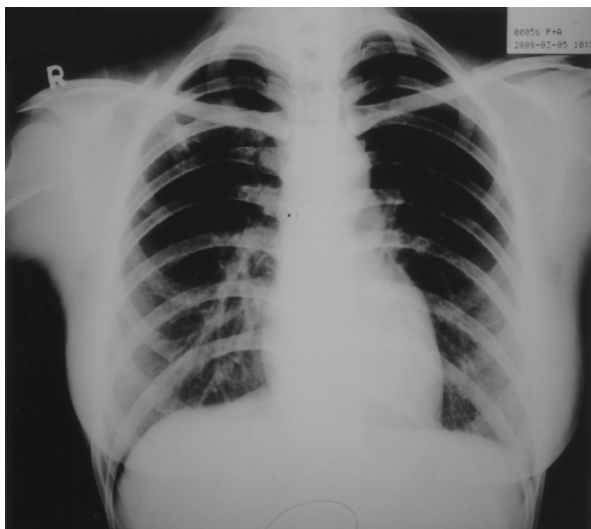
Posteroanterior chest radiograph shows right upper lung fibrocalcified lesion and left upper lung fibrosis change.
